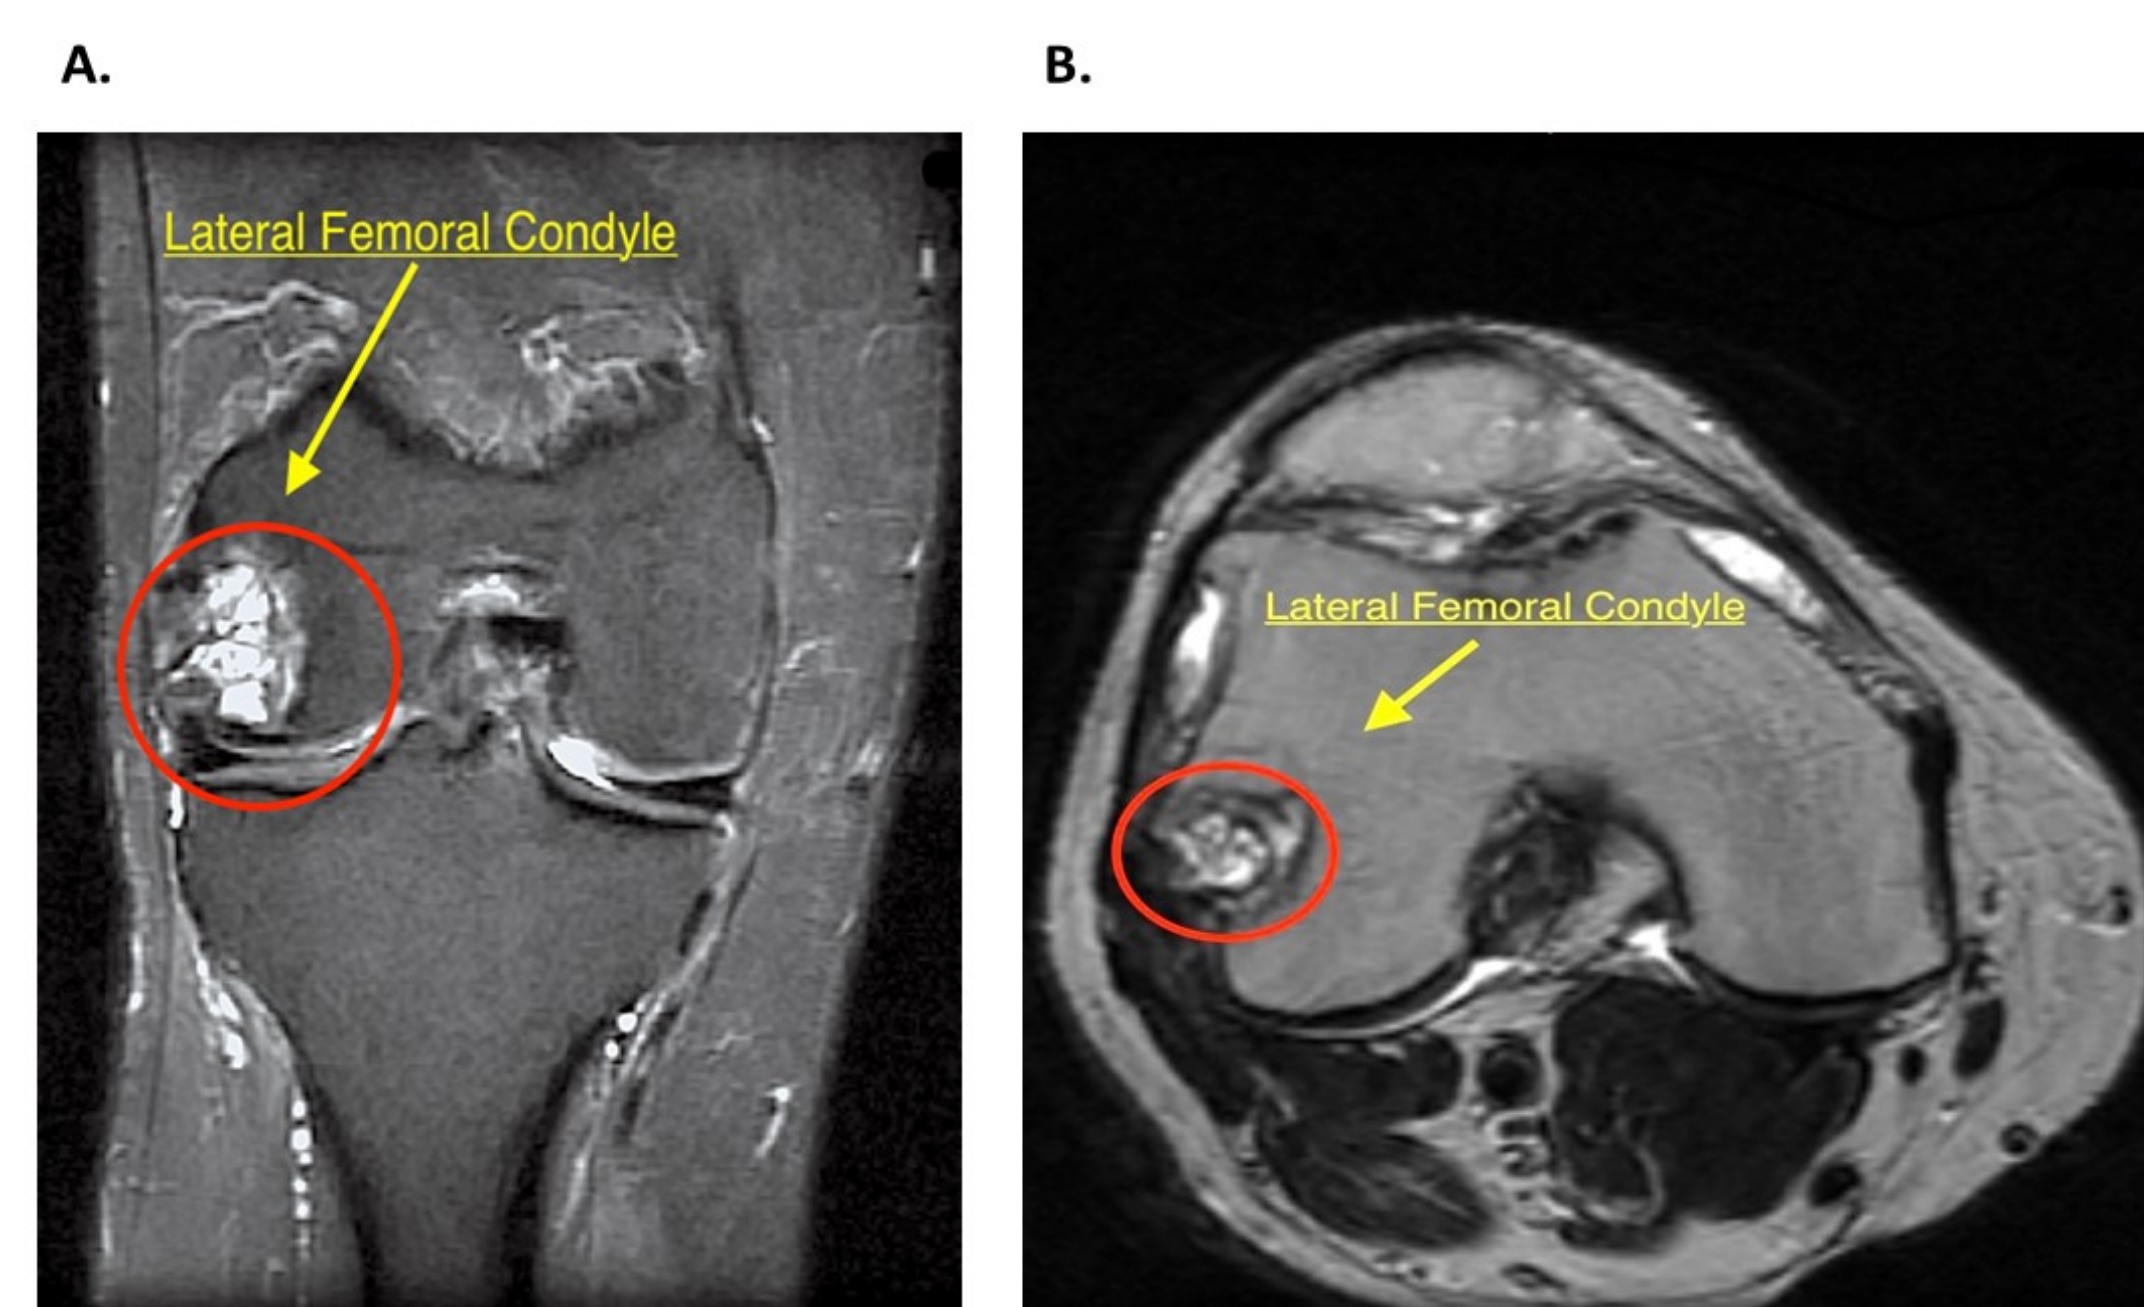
(A) Right Knee magnetic resonance image, fat-saturated FSE-IR. Coronal plane shows a multiloculated cystic area (red circle) in the lateral femoral condyle with proximal bone marrow edema. (B) Right Knee magnetic resonance image, non-fat-saturated T2 weighted. Axial plane image shows the cystic area (red circle) used for localization and planning of procedure.
